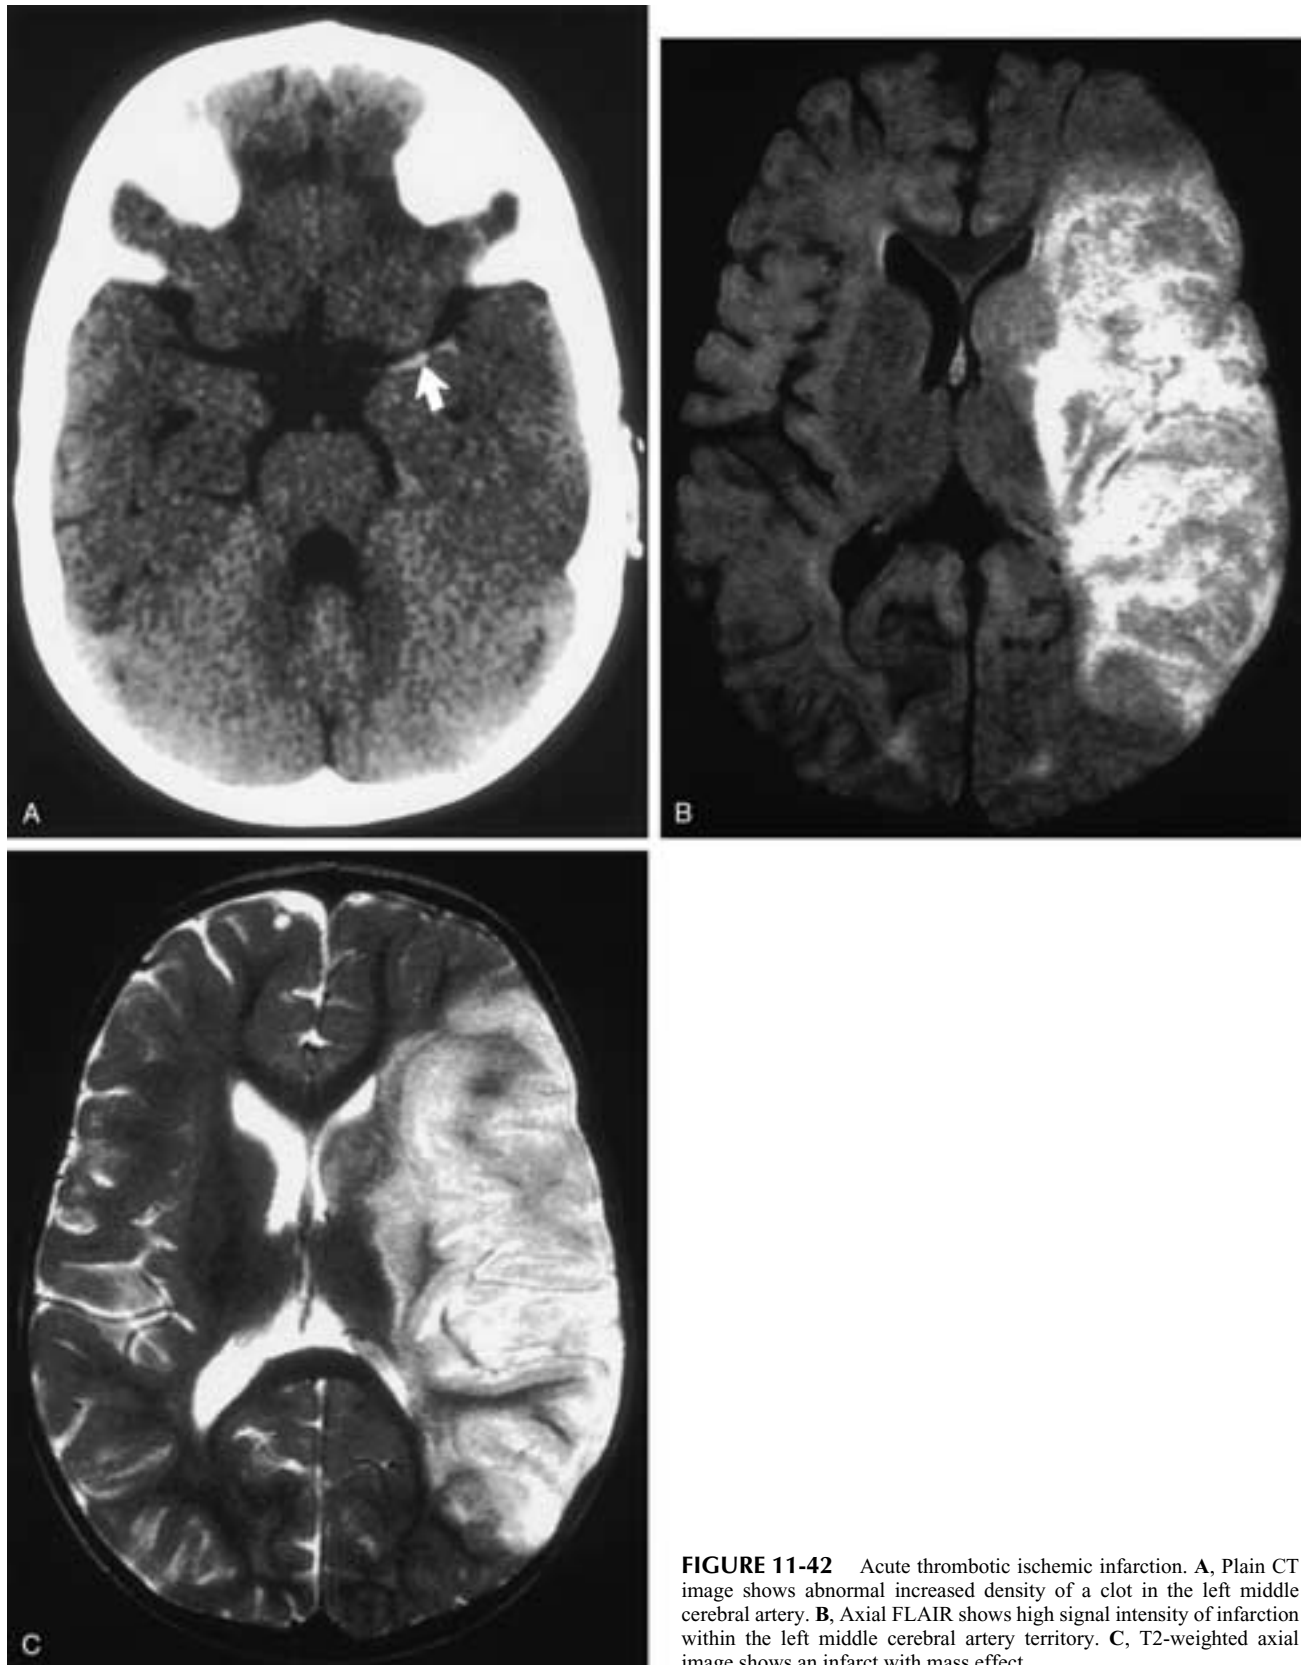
Acute thrombotic ischemic infarction. A, Plain CT image shows abnormal increased density of a clot in the left middle cerebral artery. B, Axial FLAIR shows high signal intensity of infarction within the left middle cerebral artery territory. C, T2-weighted axial image shows an infarct with mass effect.
